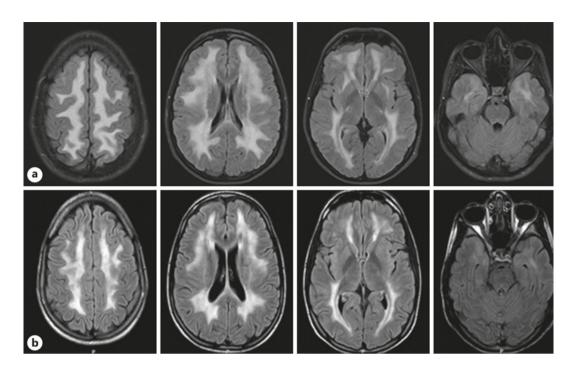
Axial and sagittal MRI FLAIR images demonstrating a diffuse leukoencephalopathy of case 1 (a) and case 2 (b).
